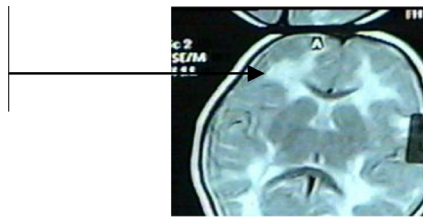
T2W brain MRI of Case 4 showing bilateral symmetric, diffuse, abnormal high signal intensity in the white matter of both cerebral hemispheres involving mainly the deep periventricular white matter (Arrow).
